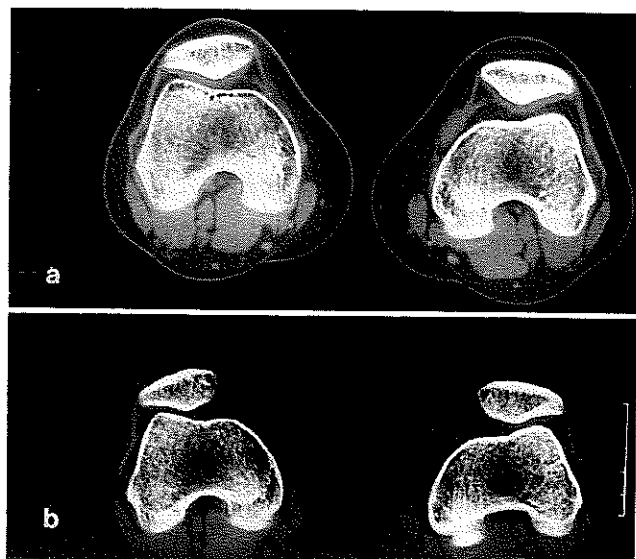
A 14-year-old patient with anterior knee pain without patellar instability. A, CT assessment with quadriceps relaxed; CA and PTA values are in the range of normal alignment. B, CT assessment with quadriceps contracted; Type II malalignment.
